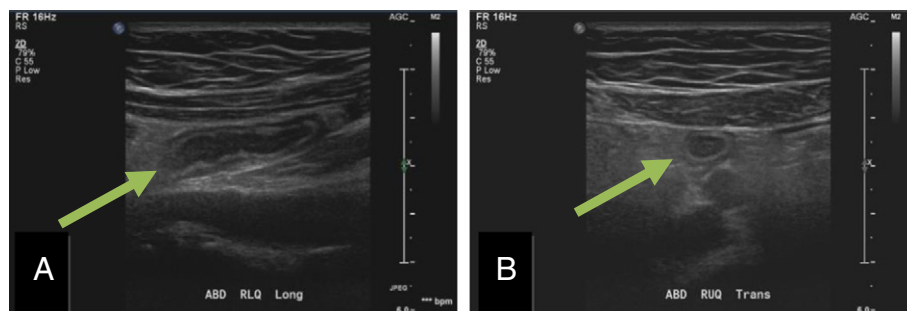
Ultrasound demonstrating acute appendicitis. A and B, Ultrasound right lower quadrant. Seven-year-old boy who presented with a 72-hour history of abdominal pain that now localizes to the right lower quadrant. Ultrasound demonstrated acute wall thickening and dilation up to 9.1 mm.
